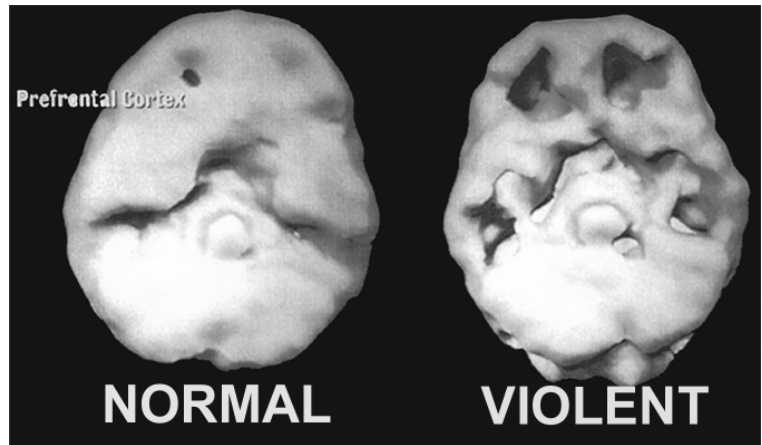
Brain SPECT imaging of normal and violent subjects.
